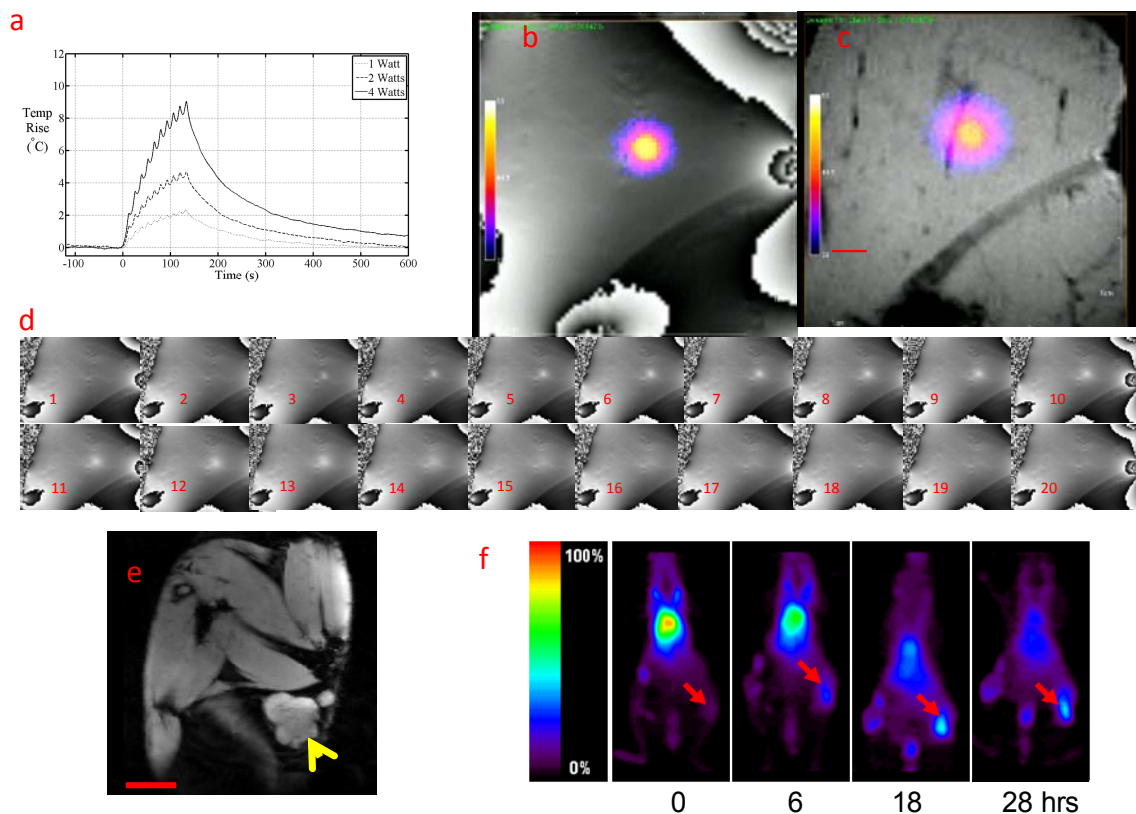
Preliminary evaluation of MR temperature mapping at high field and the use of ultrasound to enhance drug delivery. (a) Temperature validation using the Luxtron during spiral US trajectories with 1, 2, or 4 acoustic Watts of transmission for 2 minutes. Small artifacts are observed as the US scans over the Luxtron. (b-c) Phase map (b) and magnitude image (c) with temperature overlay from IGT system resulting from FLASH sequence applied to turkey breast with TR of 44.7 ms, TE of 7.4 ms, FA 10°, matrix 128x64, slice thickness 2 mm, FOV 8 cm. Ultrasound (3 MHz, 4W) was scanned in 3 mm spiral pattern. Temperature elevation was spatially mapped. (d) Subset of phase images acquired over 3 minutes before, during and after insonation applied starting in frame 3 above, insonation ended in frame 9. (e) Representative MR slice
